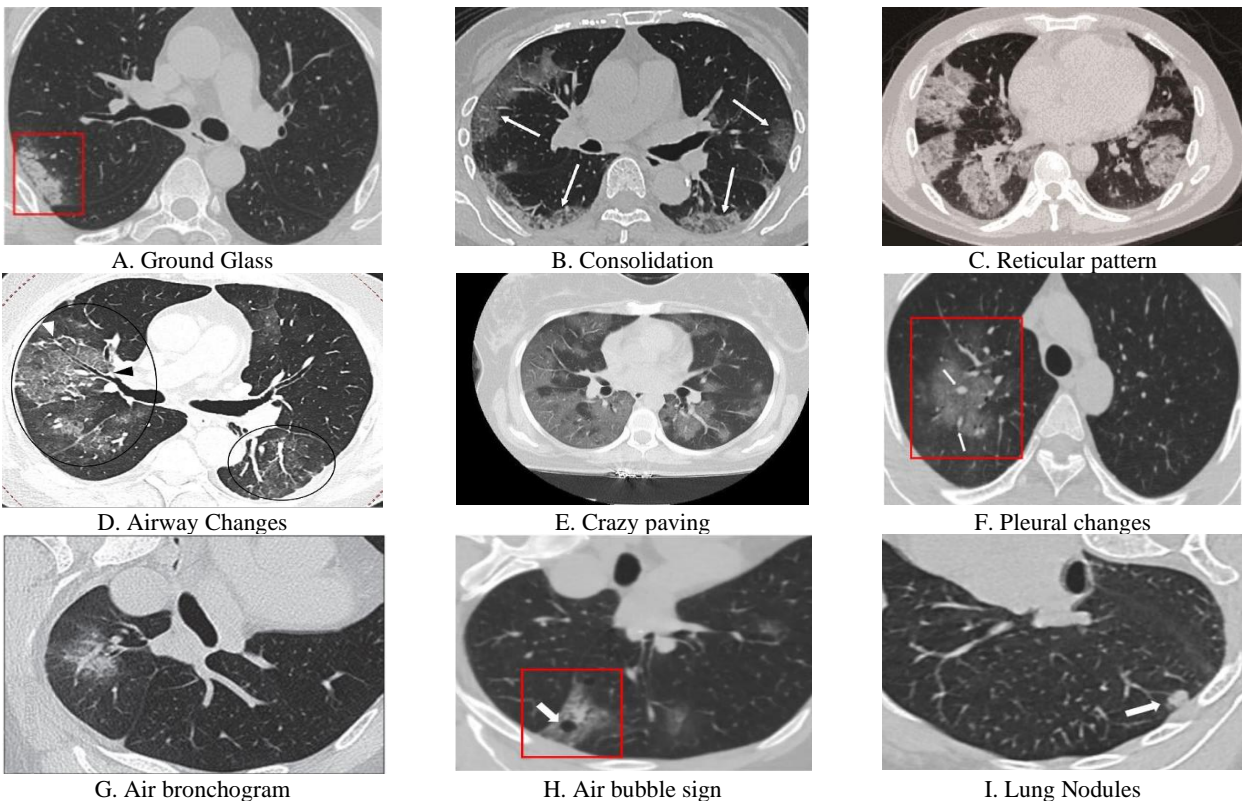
Examples of some CT features in COVID-19 patients [10], [12], [17-19].
